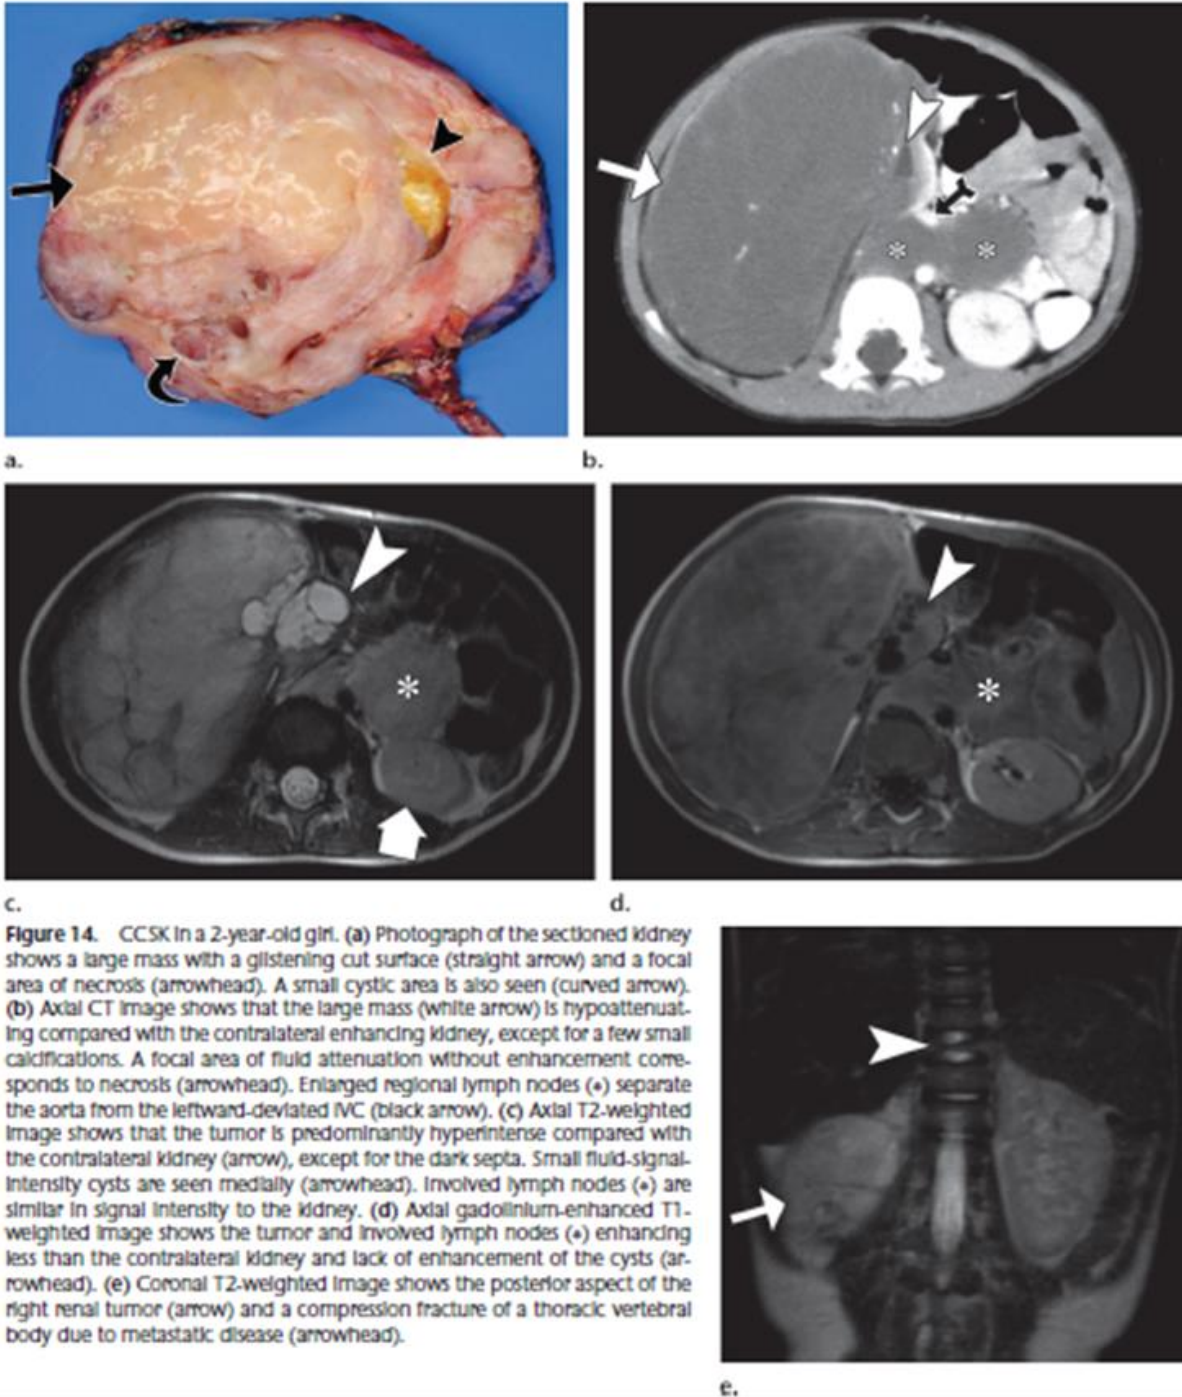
CCSK in a 2-year-old girl. (a) Photograph of the sectioned kidney shows a large mass with a glistening cut surface (straight arrow) and a focal area of necrosis (arrowhead). A small cystic area is also seen (curved arrow). (b) Axial CT image shows that the large mass (white arrow) is hypodense compared with the contralateral enhancing kidney, except for a few small calcifications. A focal area of fluid attenuation without enhancement corresponds to necrosis (arrowhead). Enlarged regional lymph nodes (*) separate the aorta from the leftward-deviated IVC (black arrow). (c) Axial T2-weighted image shows that the tumor is predominantly hyperintense compared with the contralateral kidney (arrow), except for the dark septa. Small fluid-signal-intensity cysts are seen medially (arrowhead). Involved lymph nodes (*) are similar in signal intensity to the kidney. (d) Axial gadolinium-enhanced T1-weighted image shows the tumor and involved lymph nodes (*) enhancing less than the contralateral kidney and lack of enhancement of the cysts (arrowhead). (e) Coronal T2-weighted image shows the posterior aspect of the right renal tumor (arrow) and a compression fracture of a thoracic vertebral body due to metastatic disease (arrowhead).
